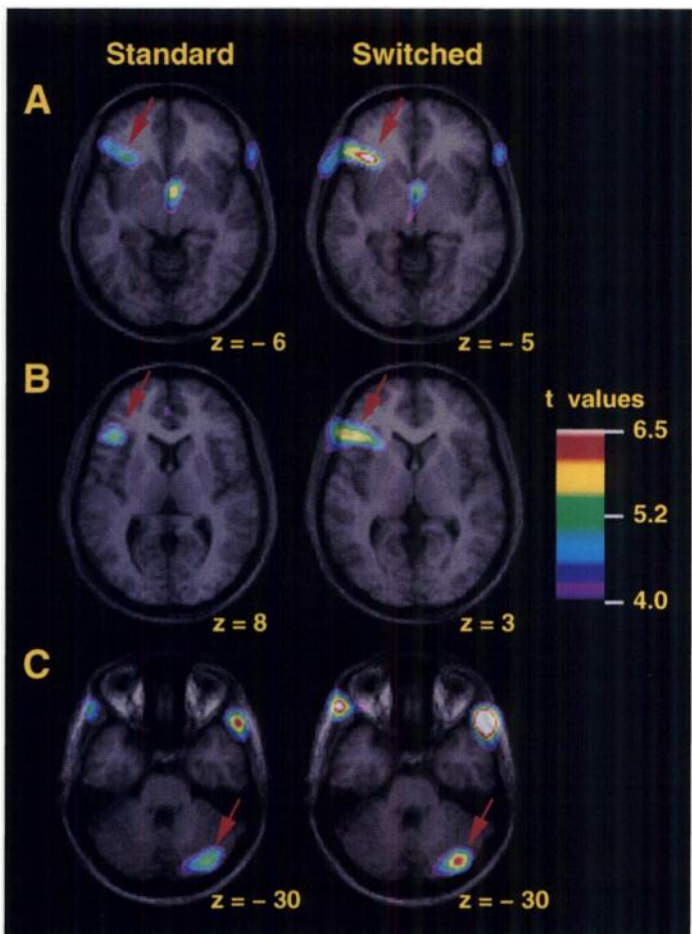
Comparison of rCBF- and switched-protocol t-statistic parametric PET images obtained from data averaged across subjects. Only foci identified as statistical significant by the rCBF protocol were used in the comparison. Nuclear MRI were superimposed on the parametric images in stereotaxic space to facilitate anatomic localization (18–20). (A and B) The left inferior frontal activations (Table 2, Foci 1 and 2, respectively), which are the most consistently activated regions during lexical search-and-retrieval tasks. (C) The right cerebellar activation (Table 2, Focus 9).
